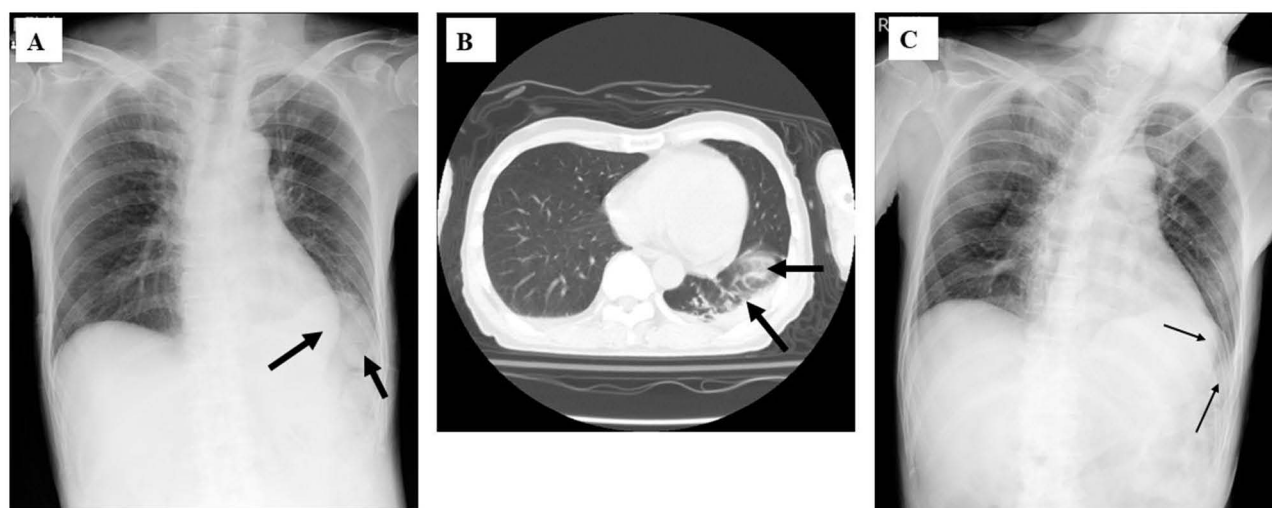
Chest X-rays (A and C) and computed tomography (B) of the Case 4 patient. At admission, there are abnormal shadows on the chest X-ray (A) and computed tomography (B), but these shadows improve after treatment (C). Arrows indicate the abnormal shadows.
